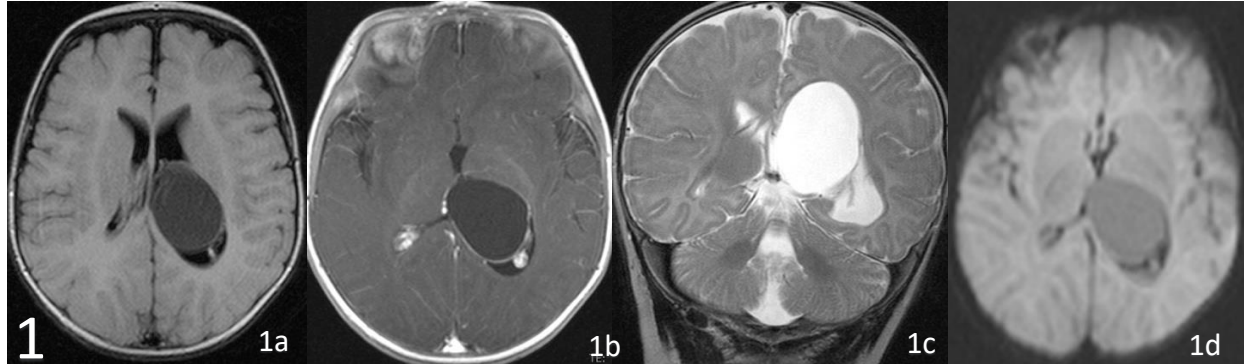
MRI of the brain performed 3 months after birth showing a left lateral Intraventricular neuroepithelial cyst hypointense on T1/FLAIR and hyperintense on T2 weighted sequence with no restriction on DWI.
